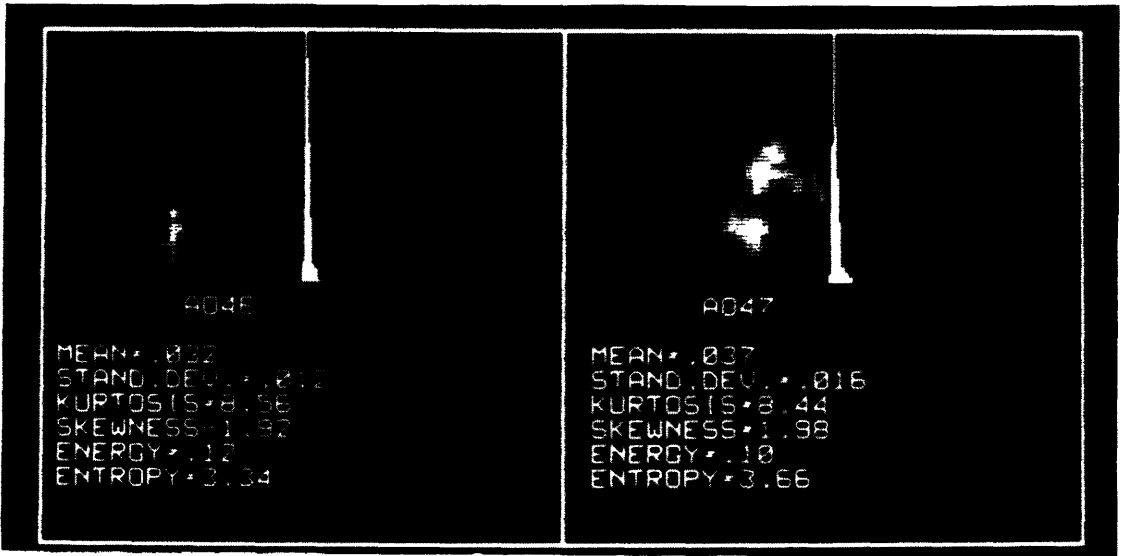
Integrated backscatter ultrasound images of two normal aortas (top left); first order histogram (top right); first order statistics (bottom).
